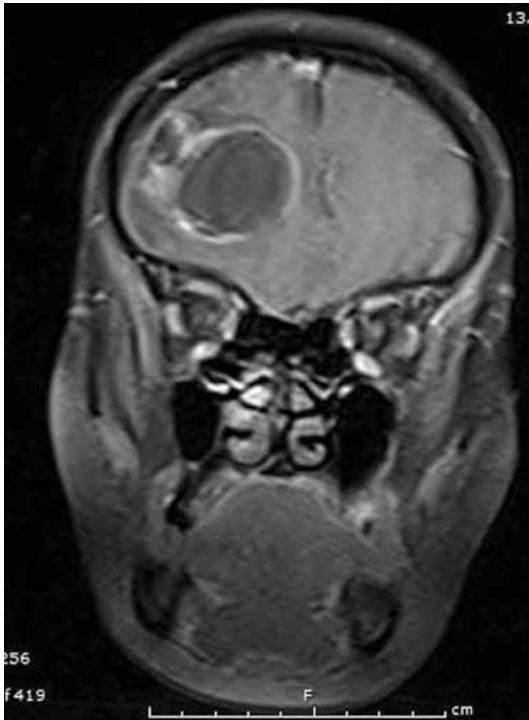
T1- weighted coronal MRI scan of the brain (after i.v. gadolinium administration). T1- weighted coronal MRI showed a lesion in the right frontal lobe.
